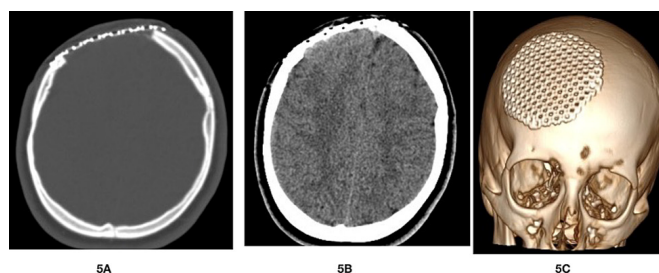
CT scan Bone window (5A), Brain Window (5B) and Volume Rendering (5C) post-surgical excision of the right frontal skull tumour with titanium mesh placement.
